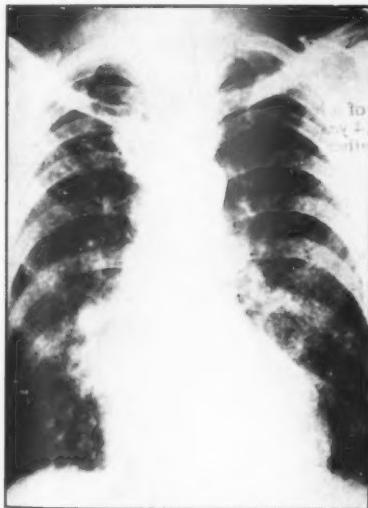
Chest radiograph of rubber worker exposed to talc dust, showing generalized nodular shadows and large heart shadow—talc pneumoconiosis.
